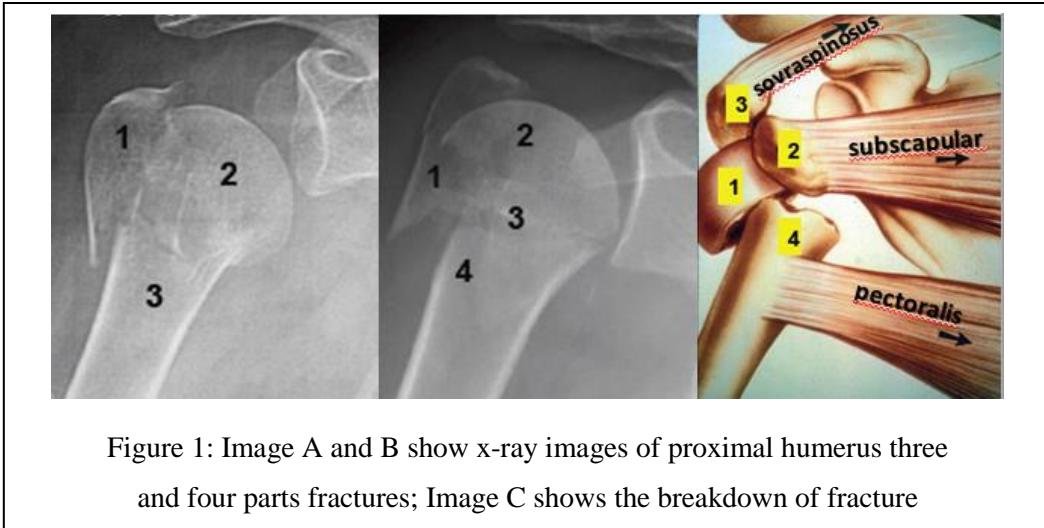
Image A and B show x-ray images of proximal humerus three and four parts fractures; Image C shows the breakdown of fracture
